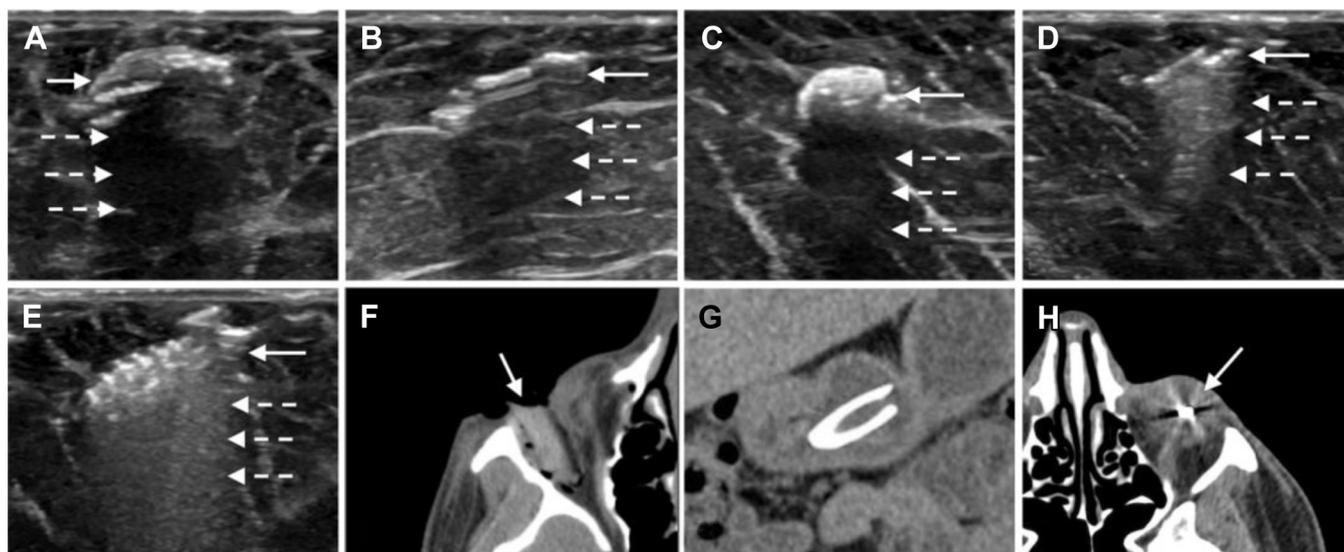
Ultrasonography (A to E) and CT (F to H) images of various materials. Wood (A), plastic (B), and stone (C) FBs appear as echogenic structures (white solid arrows) with posterior shadowing (white dashed arrows). Glass (D) and metal (E) appear as echogenic structures (white solid arrows) with ring-down artifacts (white dashed arrows). F, Intraorbital wood shrapnel (white solid arrow) can have soft tissue density after absorbing blood. With less water content, wood can also mimic air and fat density because of air content (image not shown). G, Ingested broken glass appears hyperdense without streak artifact. H, Metal appears hyperdense with streak artifacts on CT (white solid arrow).
